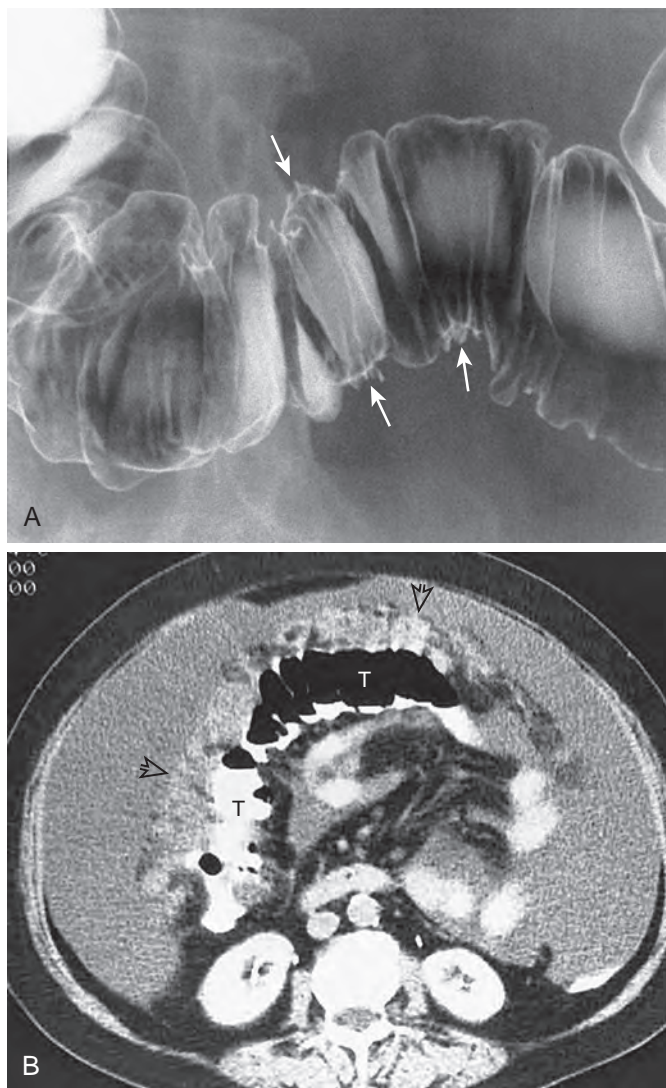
Omental cake from ovarian carcinomatosis invading the transverse colon. A. Spot image from a double-contrast barium enema shows spiculation of the colonic contour (arrows) and thin transverse stripes traversing the colon as a result of pleating of the mucosa. B. CT scan shows enlargement and increased attenuation of greater omentum caused by an omental cake (open arrows) along the anterior border of the transverse colon (T). A large amount of malignant ascites deviates the colon and small bowel loops medially. At surgery, intraperitoneal and greater omental metastases from ovarian carcinoma were found.
